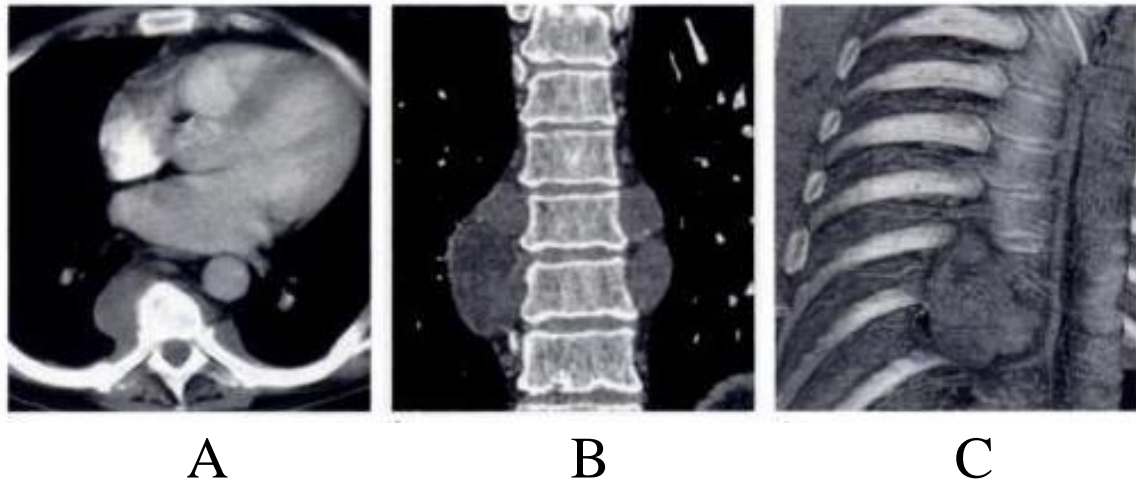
(A)CT thoracic spine show extramedullary hematopoiesis manifested by paravertebral masses of soft tissue density at the level of lower thoracic spine. (B) coronal reformation. (C) paraspinial masses in another patient.
